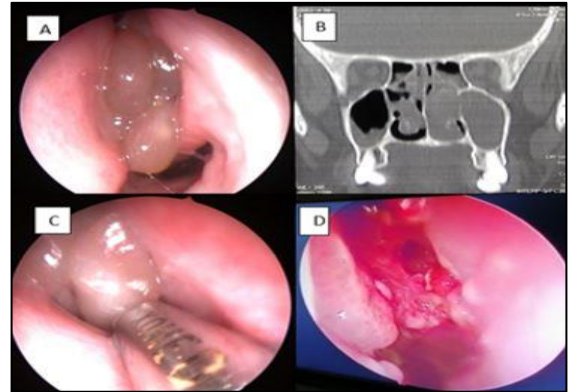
(A) DNE image of left nasal cavity showing multiple polyps in the middle meatus. (B) CT PNS coronal view showing homogenous opacity in left maxillary sinus and nasal cavity. (C) Intra-operative endoscopic image showing microdebrider assisted polypectomy. (D) Post-operative 6 weeks endoscopic image of cleared polypoidal mass.
